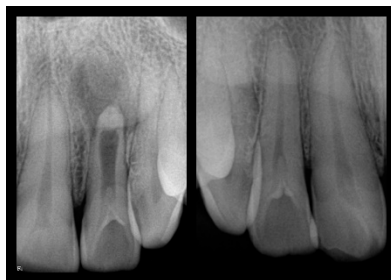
a. PA radiograph of maxillary lateral incisor #10 region at initial visit. Immature root with arrested root and spontaneous closure of the open apex is seen. A dens invaginatus type II is also noted b. A dens invaginatus type II was also seen on contralateral # 7, but root formation in # 7 was complete.
